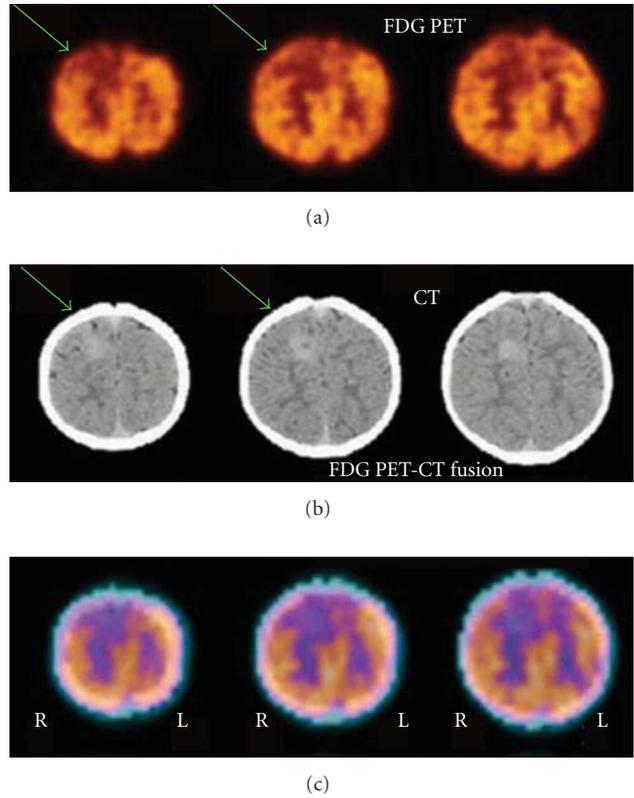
F-18 FDG PET findings in a 1-year-old boy with tuberous sclerosis. (a) FDG PET portion of PET-CT scan showed reduced metabolism in the multiple areas of the tubers, with significant reduction in the focus in the right parasagittal frontal lobe (arrow). (b) CT portion of PET-CT scan showing sclerosis in the region of the right parasagittal frontal lobe tuber (arrow). (c) PET-CT fusion image showing that the areas of decreased metabolism correspond to the prominent right parasagittal frontal lobe tuber.
